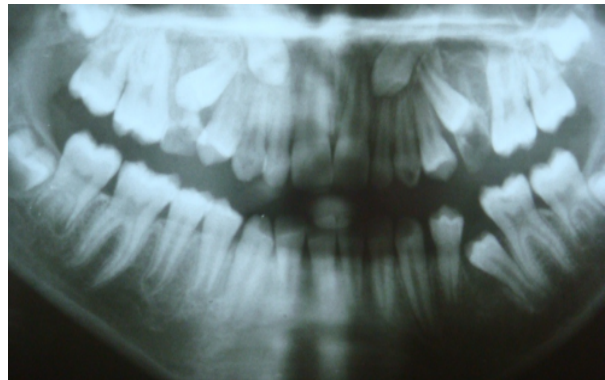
Panoramic radiograph taken 20 months after extraction of mandibular left primary second molar
